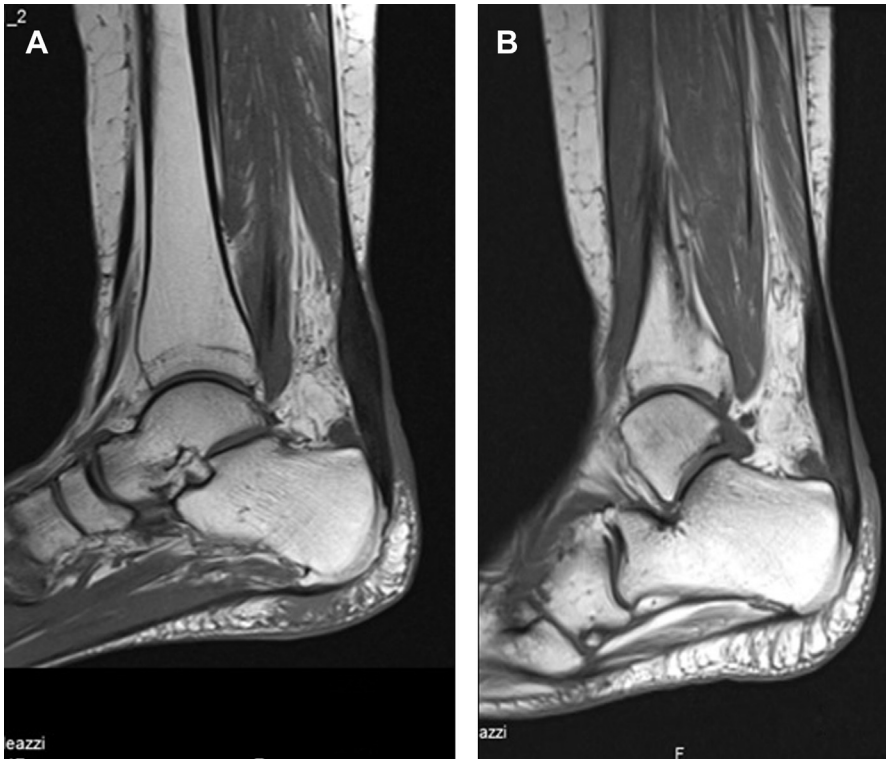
(A) Pretreatment MRI appearance of midportion Achilles tendinopathy. (B) MRI appearance of the same patient 6 months after treatment with ADSCs injections.
